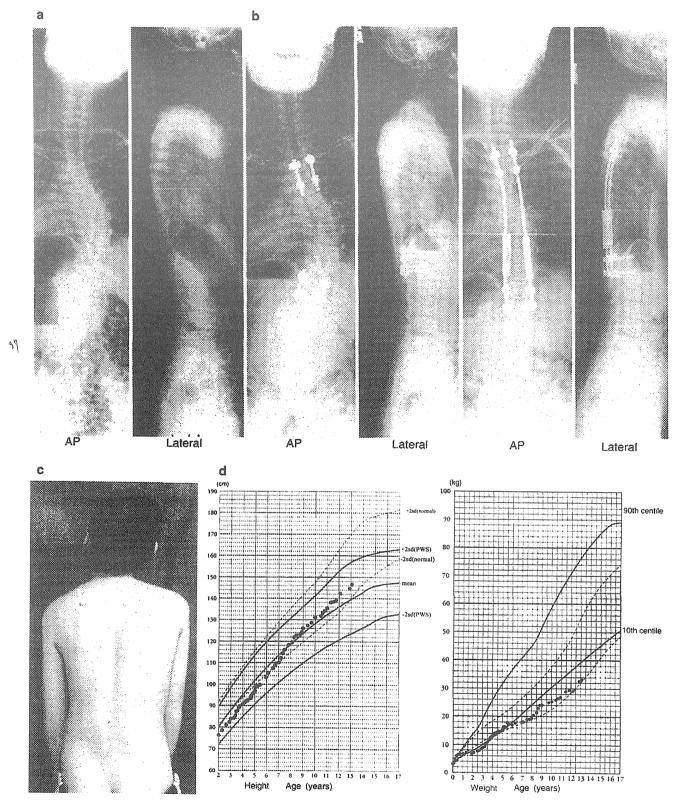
Case with the growing rod procedure, a Preoperative photograph and X-ray. b After surgery, c Final follow-up, d Height in PWS male with respect to age. Weight in PWS male with respect to age
